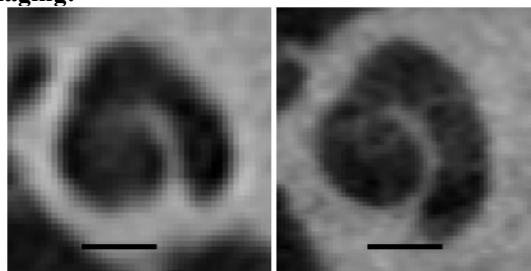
Comparison of image quality Cochlea in CT (left) and DVT (right). Bar 3mm.
